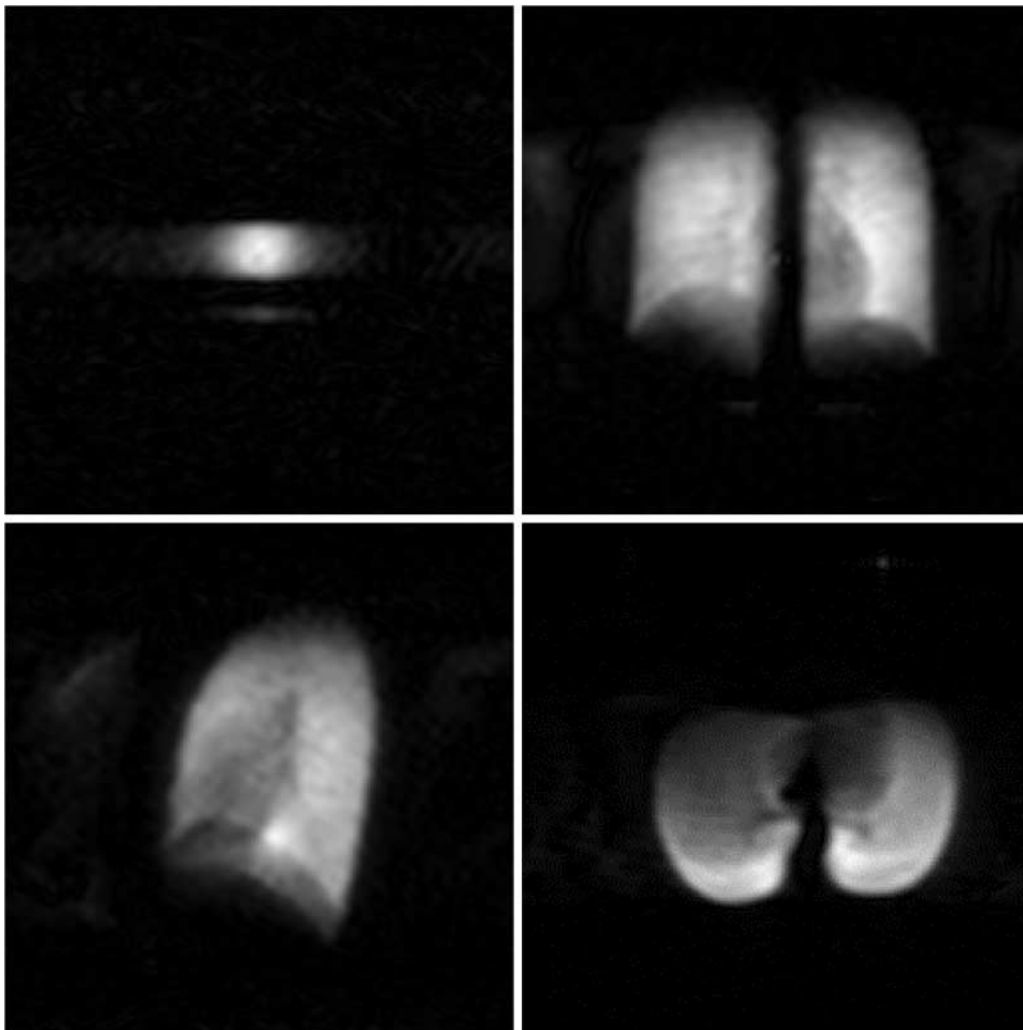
^3He OP MRI of human lungs at 0.1 T (276). Images (clockwise, from upper left): cylindrical (test) cell (5 cm diam.); and lung images through Coronal, Sagittal, and Transverse planes. The blurring artefacts caused by diffusion in the test image are greatly reduced in the lung images (see discussion in previous sections). Figures courtesy of Genevieve Tastevin.
